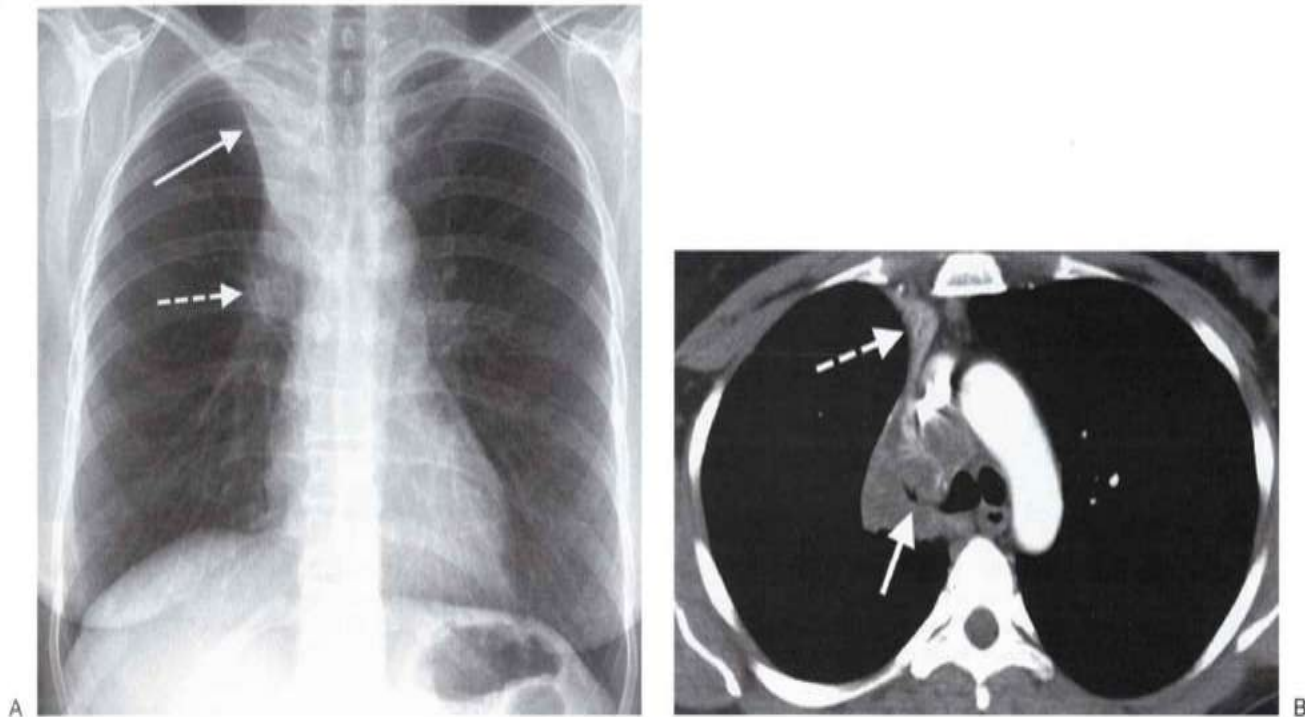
Golden S sign. A: PA chest radiograph of a man with bronchogenic carcinoma of the right upper lobe. The endobronchial tumor causes collapse of the right upper lobe, and upward displacement of the minor fissure (*solid arrow*). The tumor mass produces a convex margin toward the lung at the right hilum (*dashed arrow*). The contour of the displaced fissure and central mass creates a reverse S shape. Note the elevation of the right hemidiaphragm, another sign of right upper lobe volume loss. B: CT of the chest shows tumor encasing and occluding the right upper lobe bronchus (*solid arrow*) and collapse of the right upper lobe, with superior and medial displacement of the minor fissure (*dashed arrow*).
